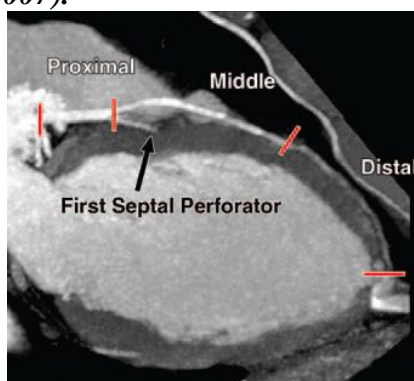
Segmentation, shown by lines, of left anterior descending (LAD) artery. Oblique long-axis reformatted CT image shows lines dividing LAD artery into three segments. Proximal segment runs from origin of LAD to origin of first septal perforator. Middle segment runs from first septal perforator halfway to apex. Distal segment runs from this point to apex itself. (*Young et al., 2011*).
